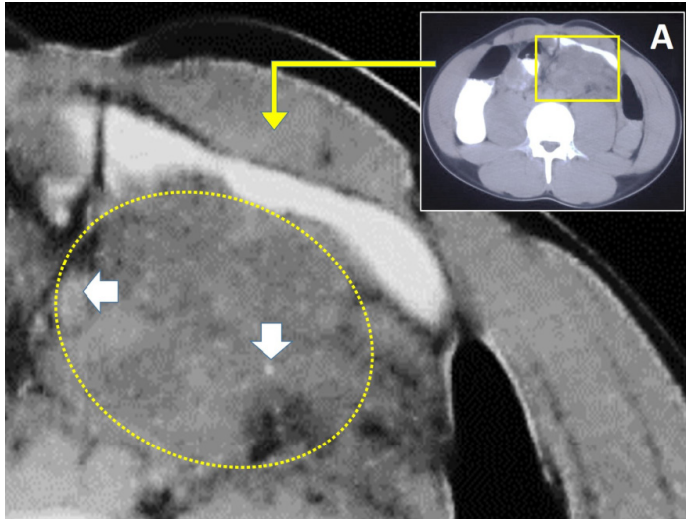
Computed tomography view, calcified, conglomerated, lymph nodes (A), and magnified form (Base)
